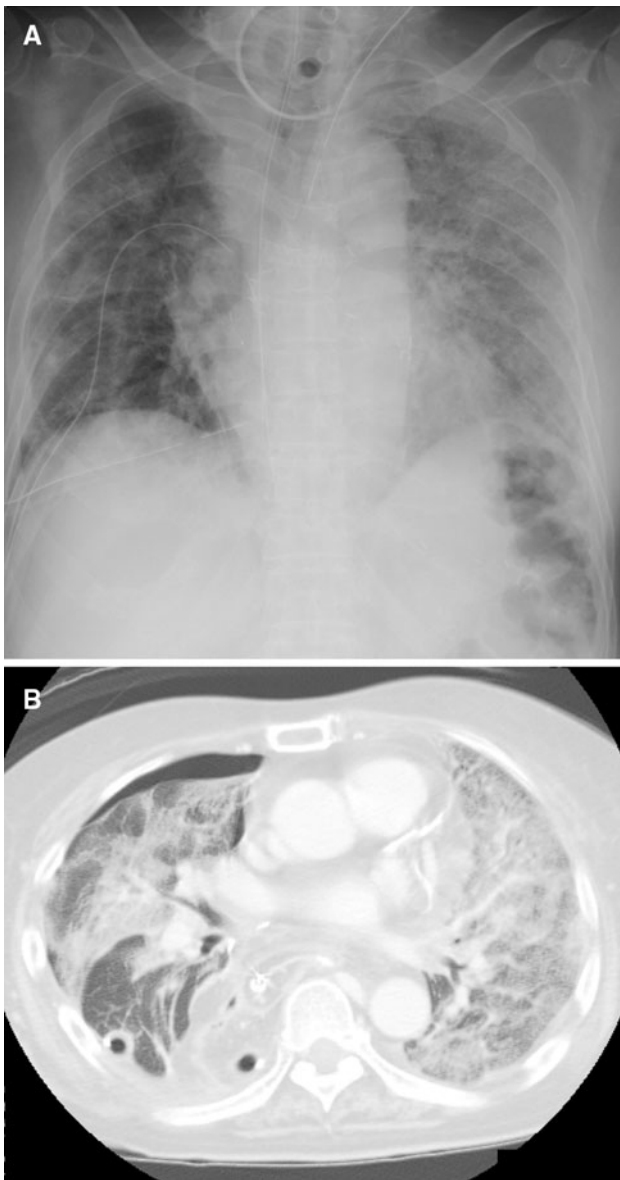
Chest X-ray (a) and computed tomography (b) of patient no. 1 at diagnosis of CMV reactivation 30 days after methylprednisolone administration
